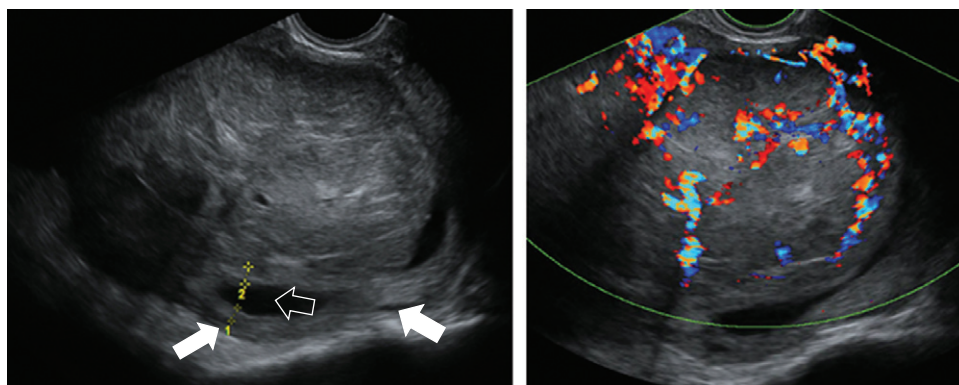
Gray-scale and color Doppler images of a sarcoma in the anterior wall of the uterus. The uterine corpus (solid arrows) is located posteriorly and contains clear fluid (open arrow).
